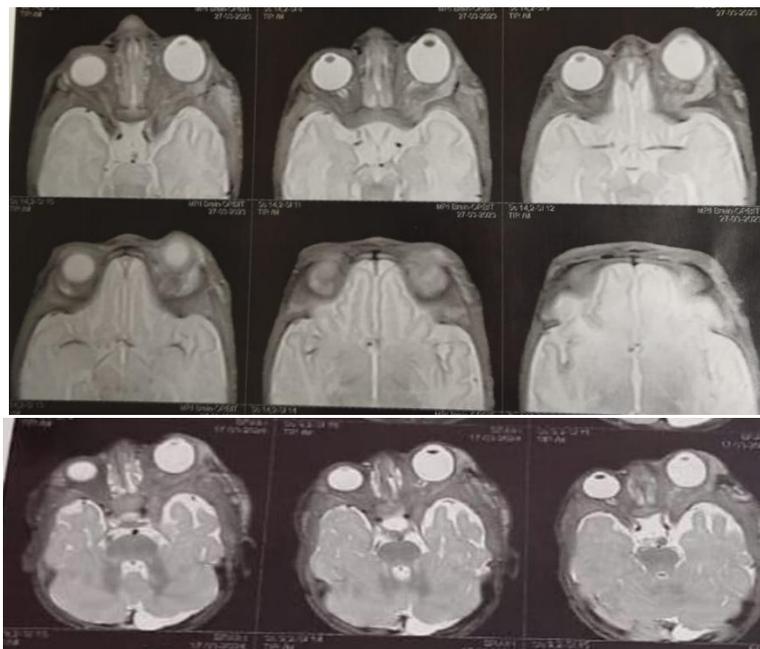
MRI showing soft tissue mass lesion in the left ptrygo palatine fossa associated with enlarged left cavernous sinus and enlarged lacrimal gland.
